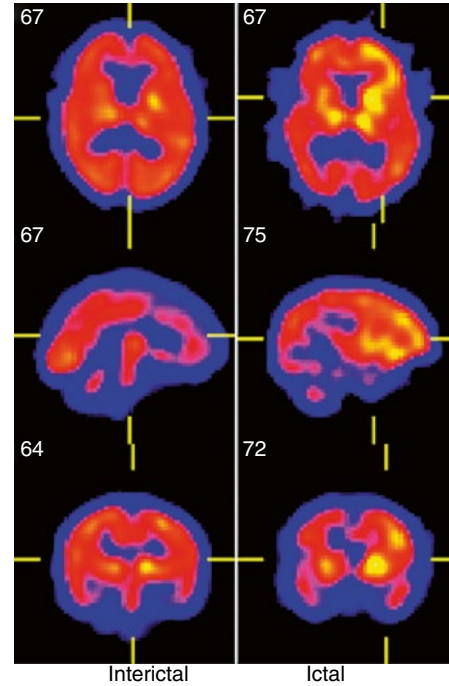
Interictal and ictal ^{99m}Tc -ECD perfusion brain SPECT. A rather large region of hyperperfusion on the left involves the frontal, parietal, and temporal regions. Increased perfusion is also seen in the central structures in the same side
